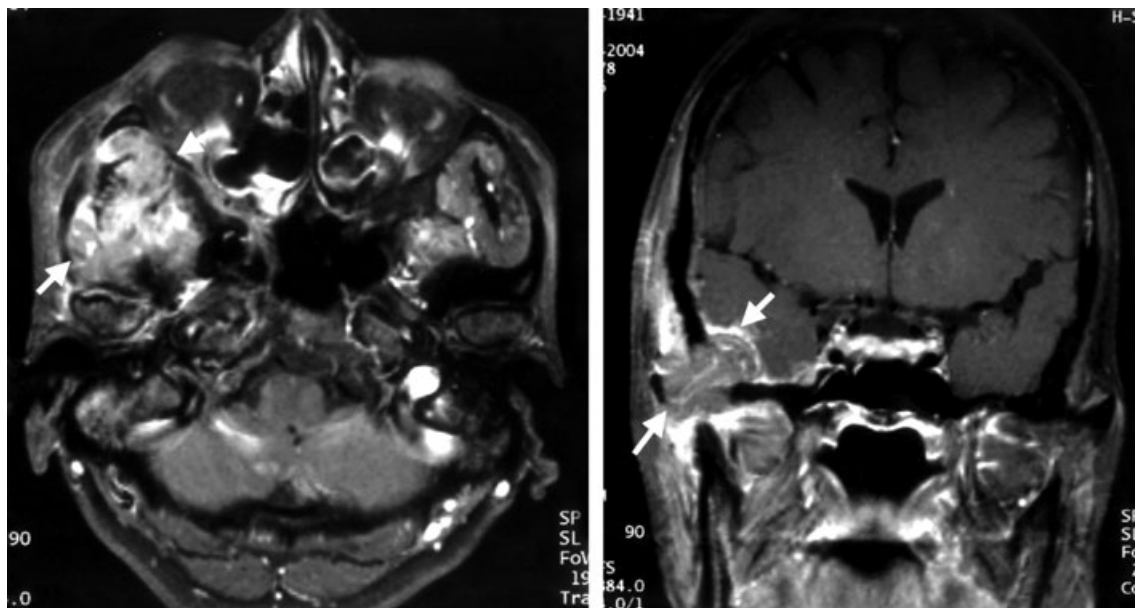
T1-weighted MR images enhanced with Gd-DTPA in April 2004. Horizontal plane (left) and coronal plane (right). The arrows indicate a mass lesion with ill-defined margins in the right infratemporal region extending to the intracranium.
